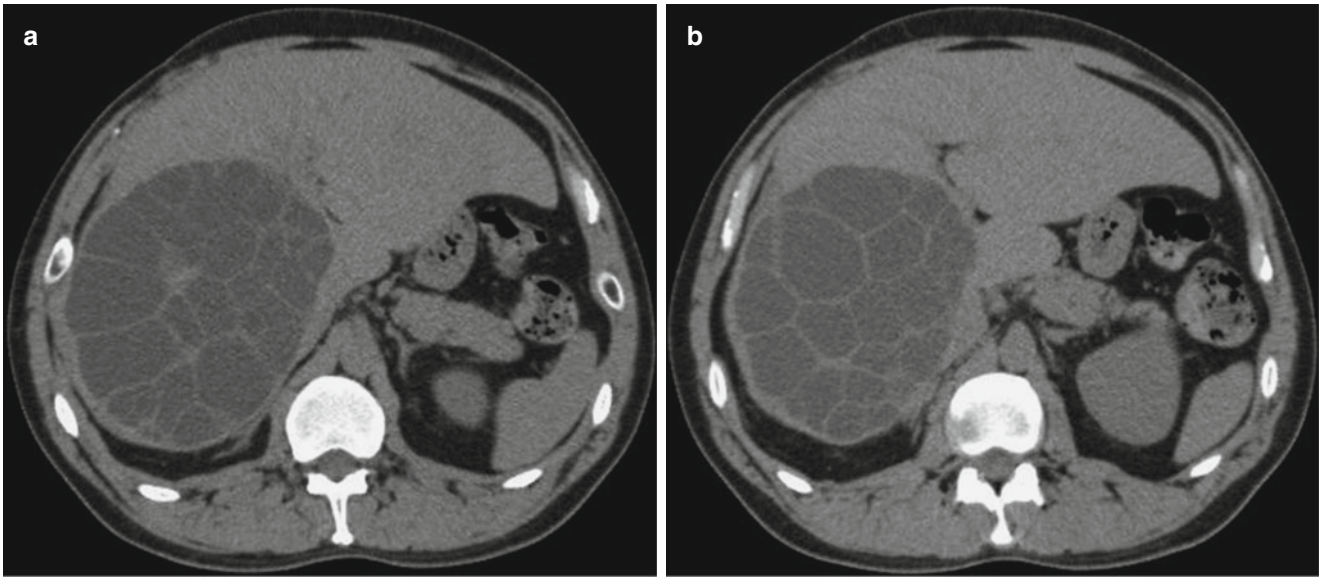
Hepatic cystic hydatidosis (multiple daughter cyst type). (a, b) Plain CT scanning demonstrates hydatidosis at the right liver lobe, with multiple daughter cysts filling up the mother cyst that compress each other in honeycomb sign
